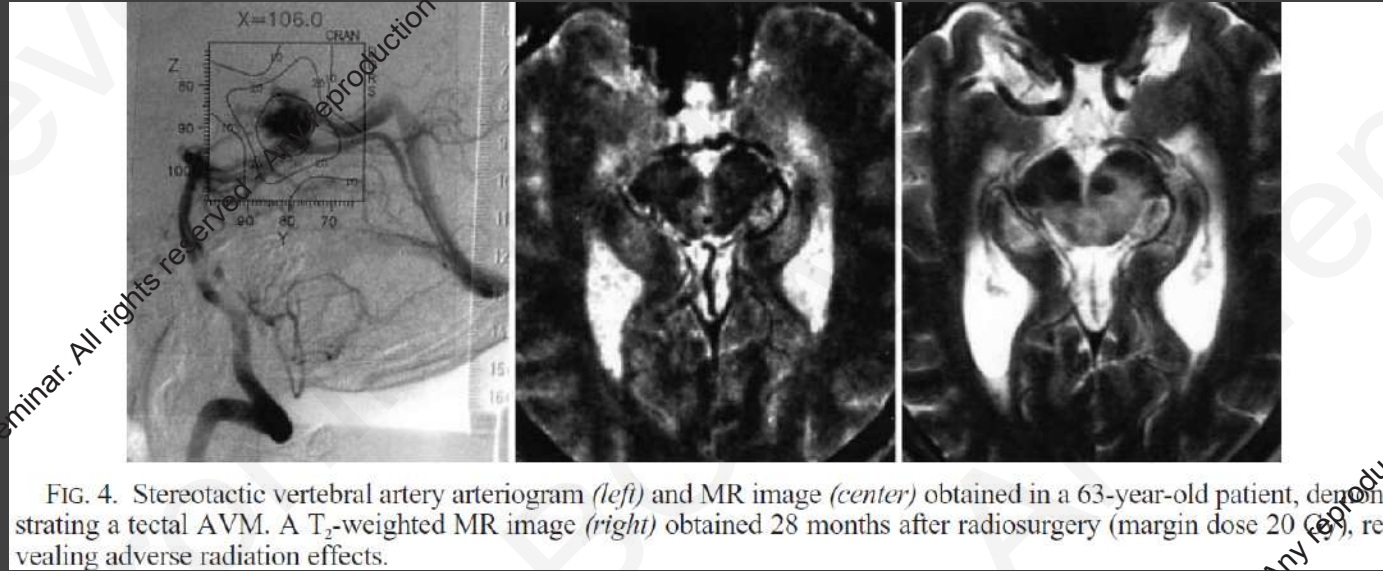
Stereotactic vertebral artery arteriogram (left) and MR image (center) obtained in a 63-year-old patient, demonstrating a tectal AVM. A T₂-weighted MR image (right) obtained 28 months after radiosurgery (margin dose 20 Gy), revealing adverse radiation effects.
